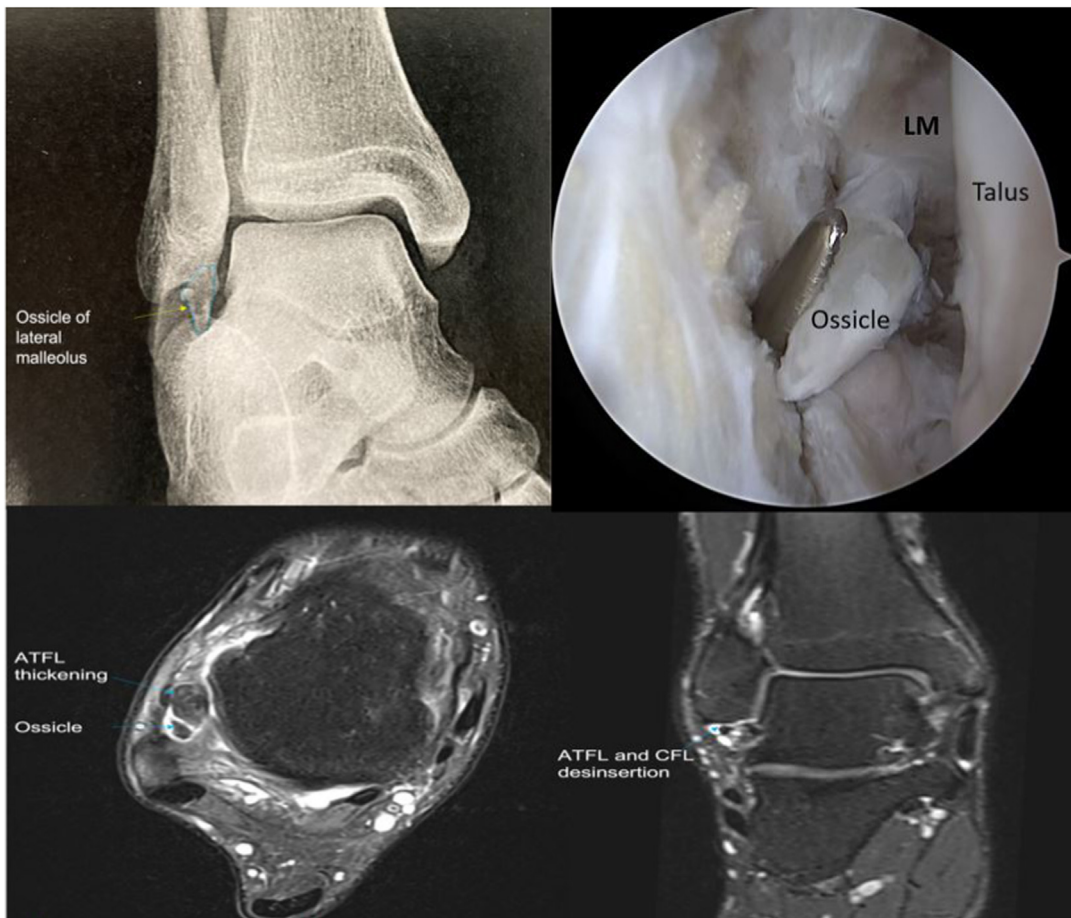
Radiograph of the ankle showing a calcification of the tip of the lateral malleolus; magnetic resonance imaging images showing calcification and detachment of the ATFL and CFL ligaments; excision of the malleolar calcification through the anterolateral portal with the arthroscope in the anteromedial portal. ATFL, anterior talofibular ligament; CFL, calcaneofibular ligament LM, lateral malleolus.
